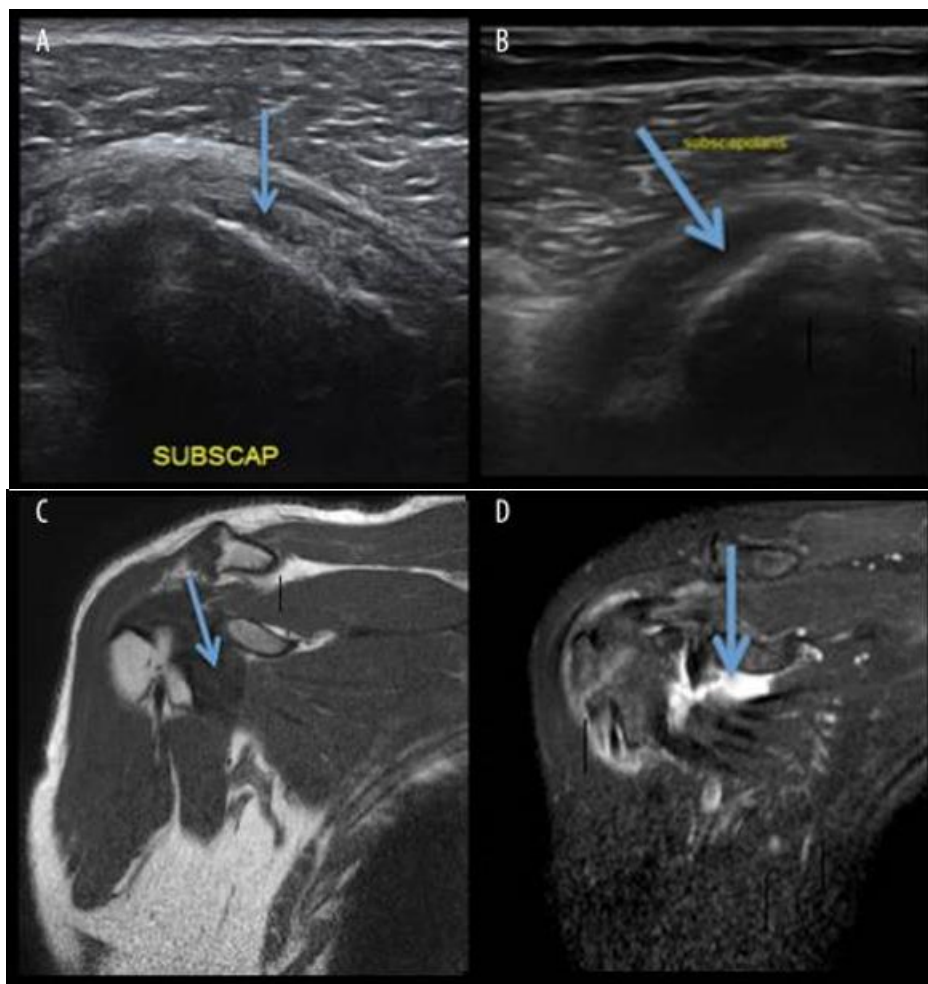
(A) USG image showing a normal subscapularis tendon (B) USG image showing a complete tear of the subscapularis tendon (C) MRI, T1W coronal image depicting a normal subscapularis tendon (D) MRI, T2W coronal image depicting a full - thickness tear of the subscapularis tendon (arrow marked).
